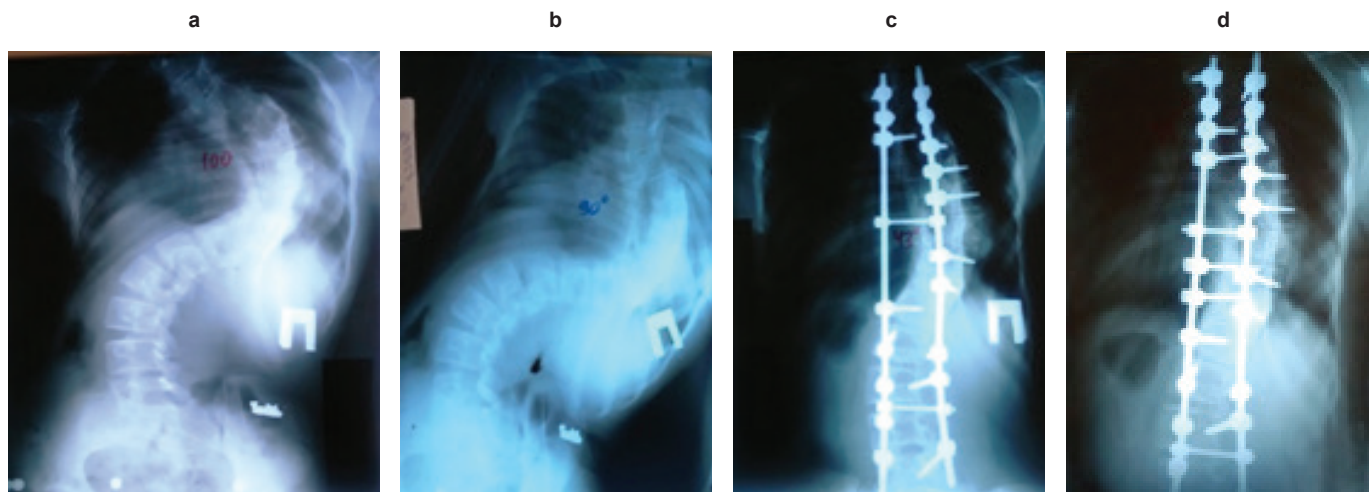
Radiographs of the patient's spine before and after surgery a) X-ray of the patient before the operation, b) X-ray of the patient before the operation in the functional position, c) X-ray of the patient after the operation d) X-ray of the patient after the second operation of additional correction.
